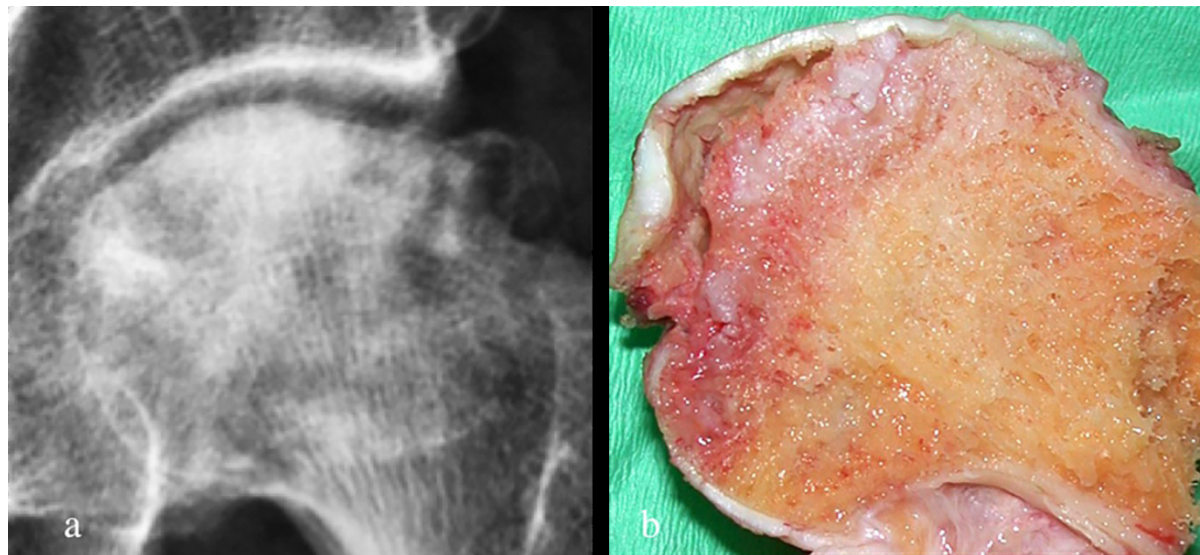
Progressive joint degeneration in late stages of FHOn. (a): Preoperative radiographic appearance of femoral head advanced collapse due to On. (b): Pathologic appearance of the bisected, excised, femoral head.
